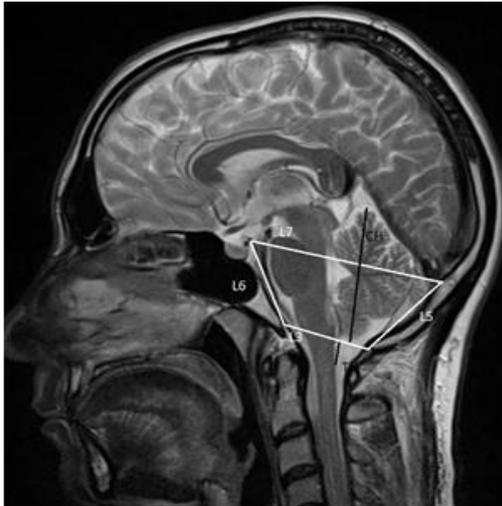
Demonstration of morphometric measurements performed on the midsagittal line on T2-weighted Cranial MRI
